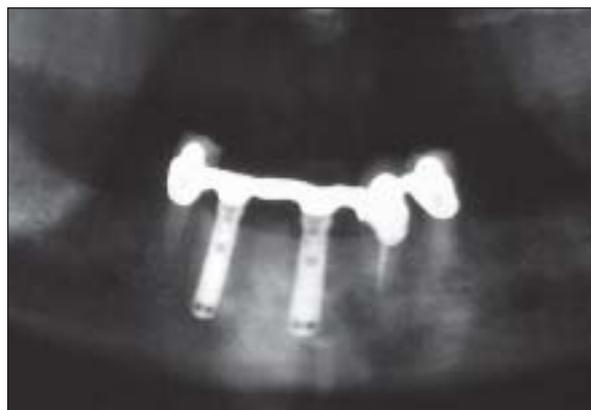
Panoramic radiograph taken after periodontal and surgical treatment.
